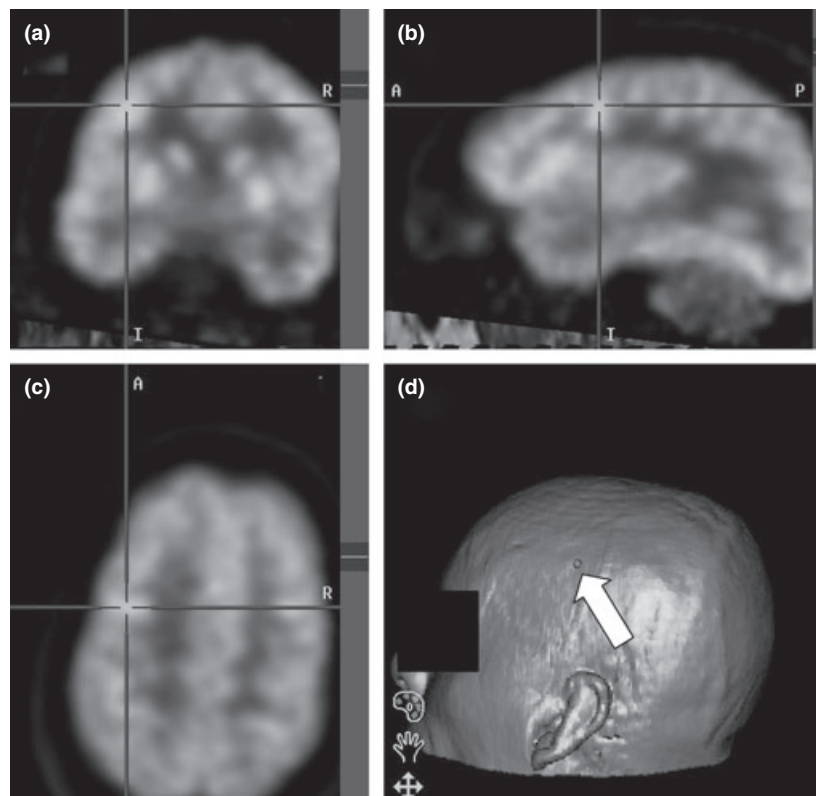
Coronal (a), sagittal (b) and axial (c) views from merged FDG-PET/MR images via StealthStation system (Medtronic) demonstrate a hypermetabolic focus over left middle frontal gyrus. Three-dimensional image (d) shows relative position of the seizure focus (arrow) superior to the patient's left ear. These images were captured when the lesion had been partially resected, with the Stealth probe placed in the resection cavity.
